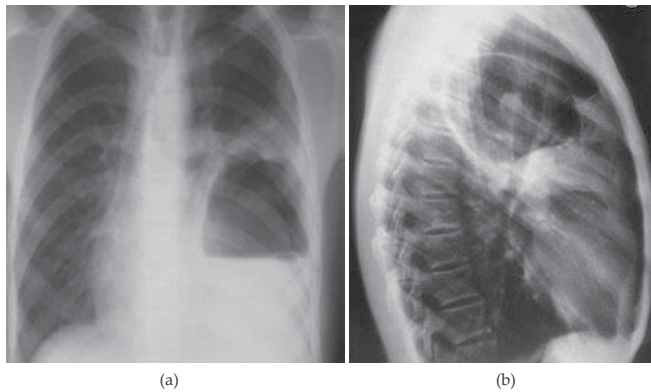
(a) Postero-anterior and lateral (b) chest radiographs showing a cavitory lesion located at the left paracardiac region in the left hemithorax with an air-fluid level having a convex serpiginous margin with heterogeneous contents
